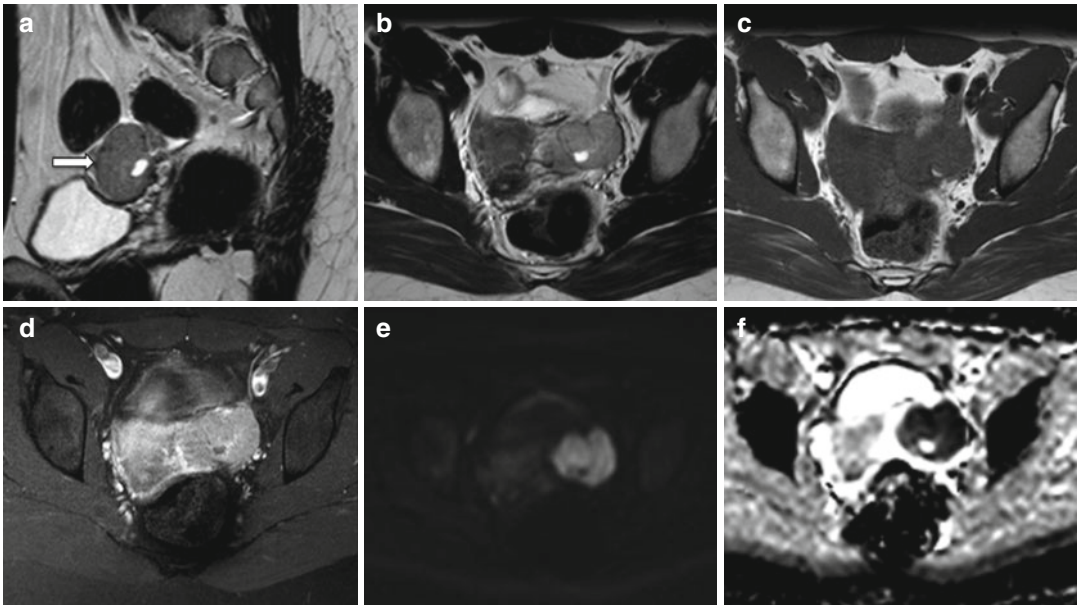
Poorly differentiated Sertoli–Leydig ovarian tumor. Left-sided solid ovarian mass (*arrow*) in a 23-year-old patient with oligomenorrhea and excessive hair growth. The mass demonstrates intermediate signal intensity on T1- and T2-weighted images (TR:519, TE:10
